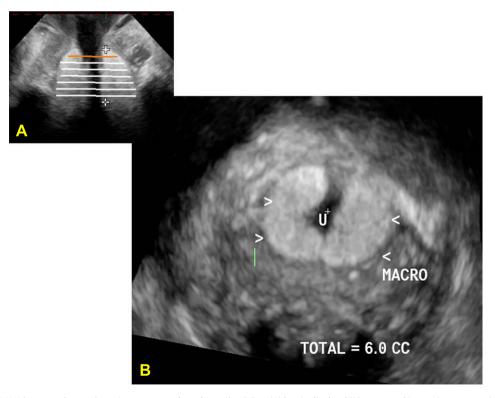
Macroplastique on 3DUS has a very hyperechogenic appearance along the urethra (U) on (A) longitudinal and (B) transversal images in a naïve patient who was dry after one injection. 3DUS = three-dimensional vaginal ultrasound.
